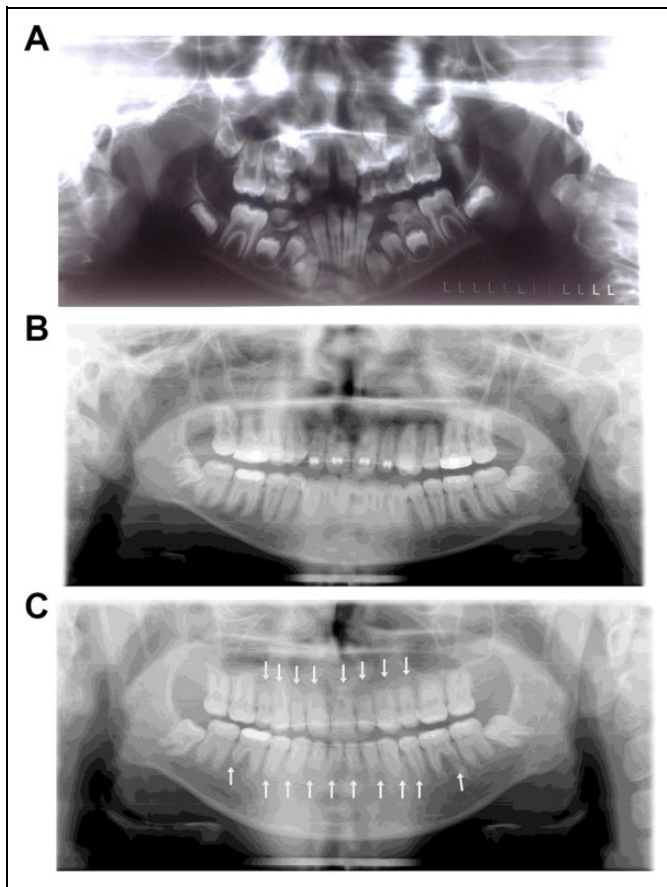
Panoramic radiographs: (A) taken at the age of 7 showed normal appearance of teeth; (B) taken before the orthodontic treatment at the age of 14 showed short roots and wide chambers of all incisors, large pulp chambers of molars and premolars with deposits of hard tissues in the form of a denticle; (C) taken 6 months after debonding of orthodontic appliances showed shortening of roots, except for the upper molars and the lower second molars.
